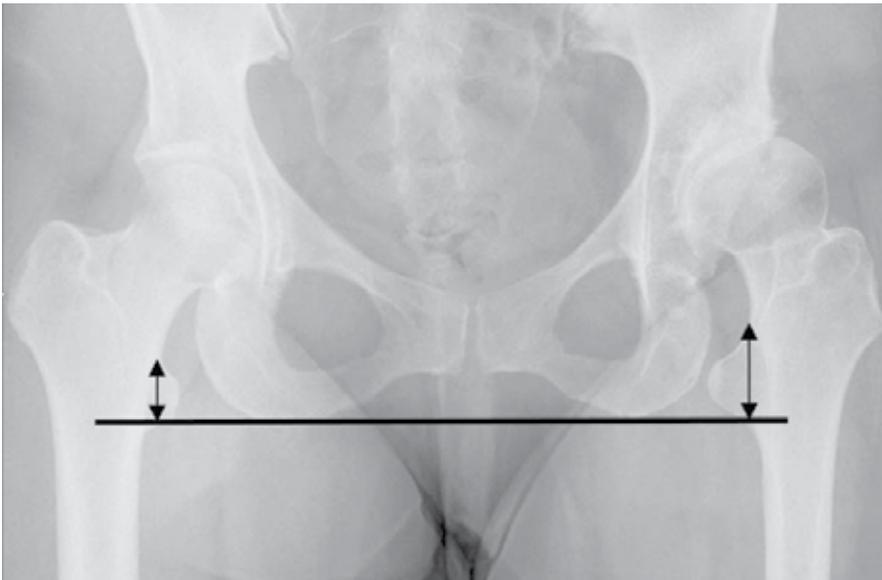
Radiographic estimation of LLD can be made by measuring vertically from the top of the lesser trochanter to a line drawn across the inferior margin of the pelvis
